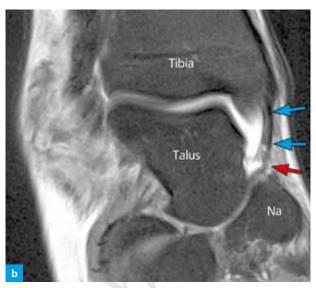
MR-imaging of tibionavicular ligament (TNL). (a) Standard coronal intermediate-weighted MR image with fat-suppression of a 21-year-old hockey player after ankle trauma. The arrows mark the course of the TNL. Due to the partial volume effect, the TNL is not clearly demonstrated. (b) Corresponding secondary reformations of the standard images in Fig. 2a in a 20° coronal-oblique plane along the course of the TNL. The reformations were performed on a standard PACS work station. The blue arrows show the course of the whole TNL from the origin at the anterior tibia to the insertion at the navicular bone (Na). In this reformation, the distal partial tear is obvious (red arrow).
